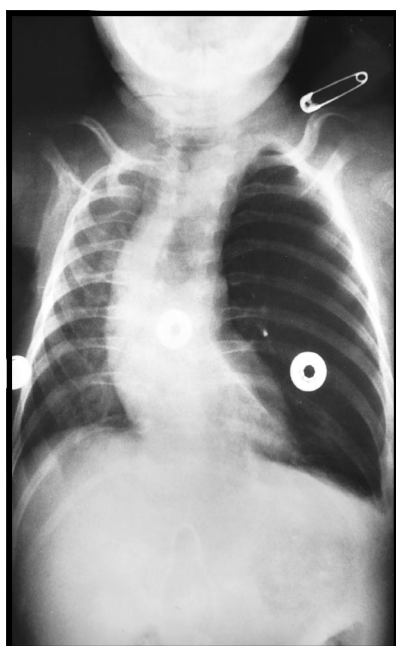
Chest radiograph of patient number 3 showing massive distension of the left upper lobe. Note also the mediastinal shift and herniation of the distended lobe to the opposite side.
